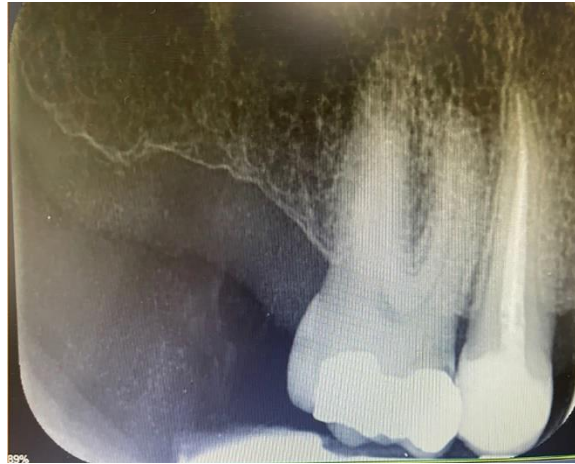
Preoperative Radiographic view of teeth #16 with amalgam restoration and secondary caries
